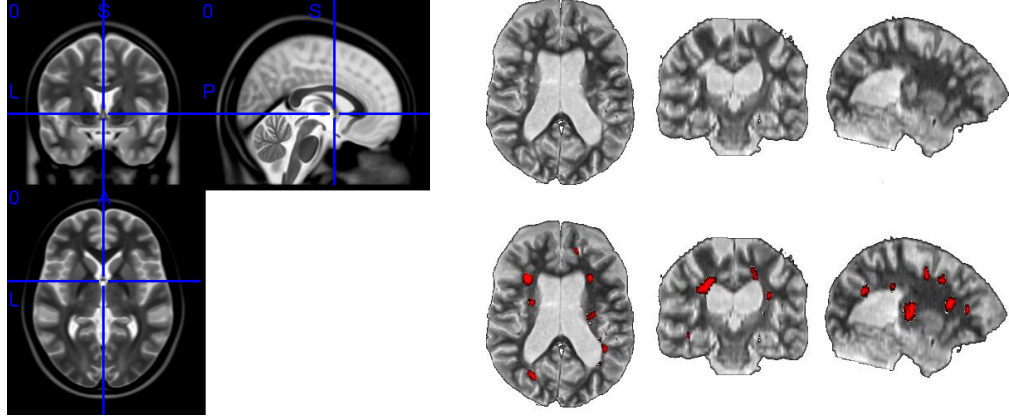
Left panel:* Example MRI of a standard brain template, showing coronal (upper left), sagittal (upper right) and axial (bottom left) views. The crosshairs indicate the origin in MNI space. *Right panel:* Example MRI of an MS patient with and without colouring of lesions on a T₂-weighted scan. The subject shown is part of the GeneMSA data set.
